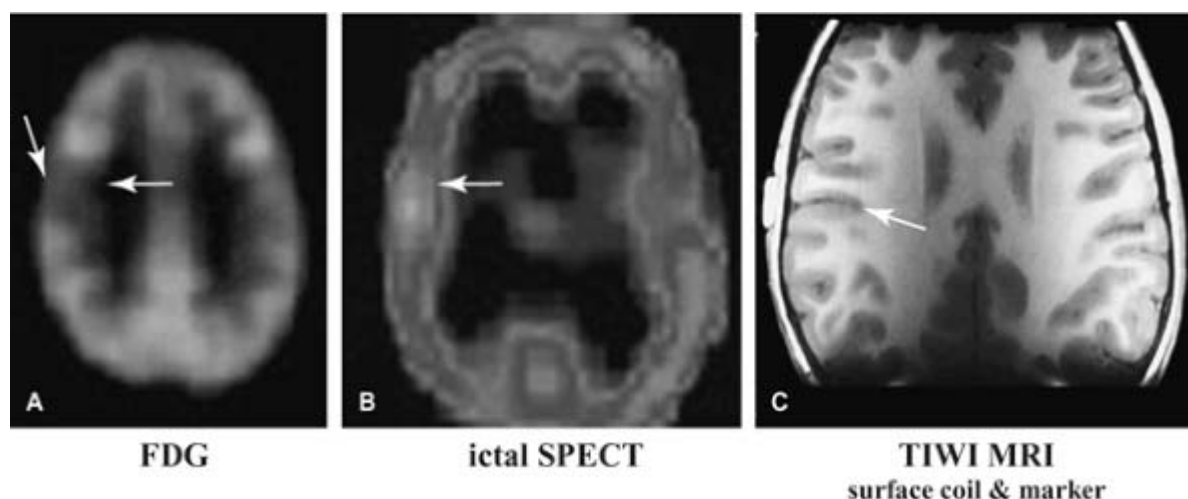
Simple partial seizures with right face sensation and jerking. In many cases of partial epilepsy the initial magnetic resonance imaging shows no abnormality. The patient had simple partial seizures with a sensation in the right face and jerking of the face. Fluorodeoxyglucose (FDG) positron emission tomography (PET) (A) showed a clear focal abnormality that accords with the increased perfusion on ictal single photon emission computed tomography (SPECT) (B). Careful analysis of the magnetic resonance imaging (MRI) and a further surface coil study with a fiducial marker (C) revealed a focal abnormality. In this case a small “bottom of the sulcus dysplasia” was identified. Surgery of this small focal area led to seizure freedom. T1WI, T1-weighted imaging. (Case courtesy of Simon Harvey, Royal Children's Hospital, Melbourne, Australia.)
